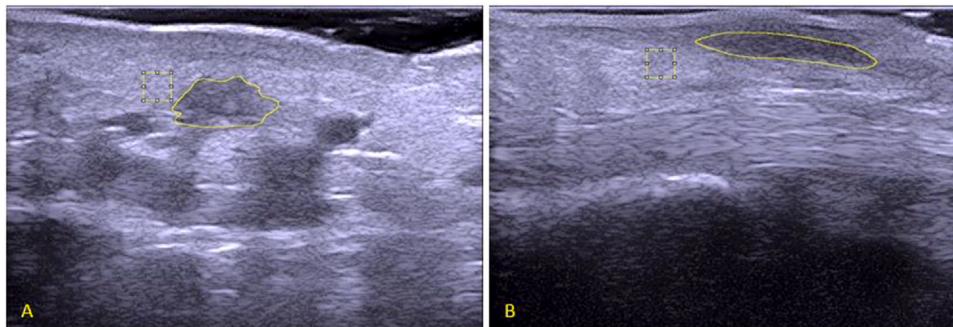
Ultrasound images on which the outer border of a nodule is indicated, as well as the reference frame (square). A) Transversal plane and B) sagittal plane.
